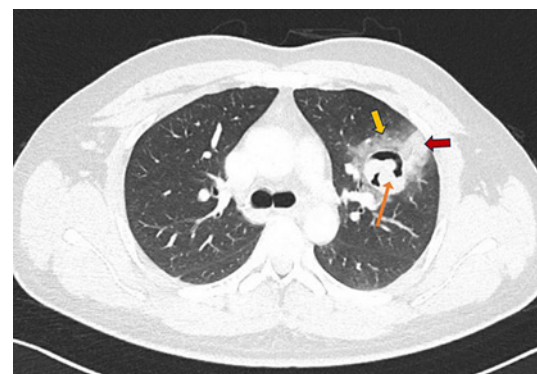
Interval 2nd CT scan of the chest: An increase in the “soft tissue” component of the lesion was noted on the interval scan (orange arrow). Perilesional consolidation (red arrow) and ground-glass changes (yellow arrow) were also present. A rim of air was again observed surrounding the intracavitary mass lesion.
